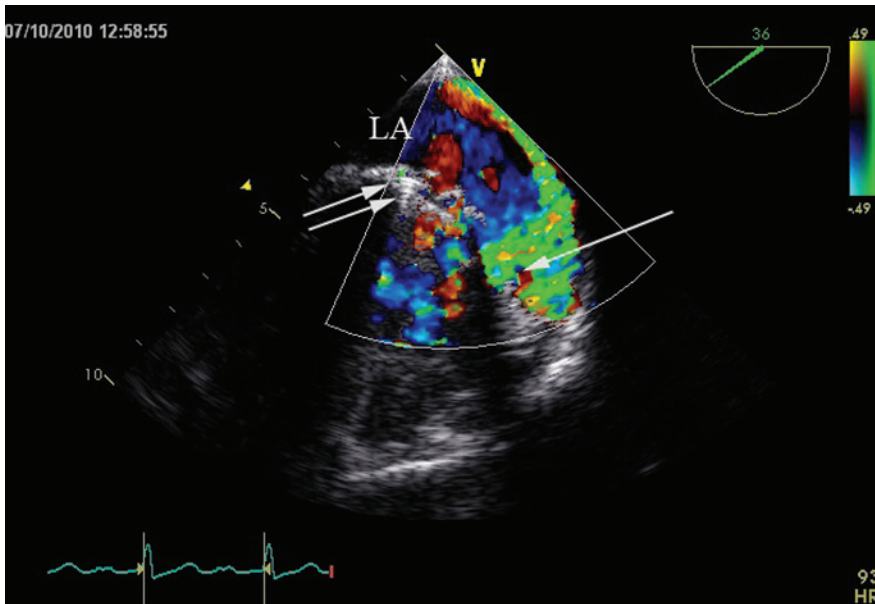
Sample transthoracic echocardiogram with color Doppler imaging. The prosthetic mitral valve (double arrow) with paravalvular leak (single arrow). LA, left atrium.
